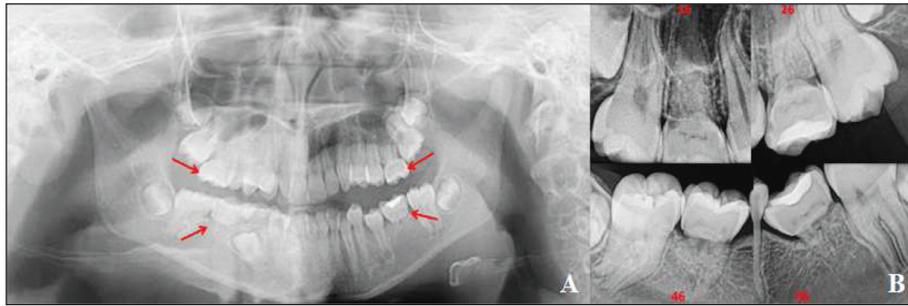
Panoramic radiograph before orthodontic treatment (1A). Periapical radiographs of teeth 16, 26, 36 and 46 (1B). The anomaly was diagnosed with molar-incisor malformation since the stunted and insufficient root development of the permanent first molar teeth was accompanied by a clinically normal-appearing crown and abnormal pulp chamber.
